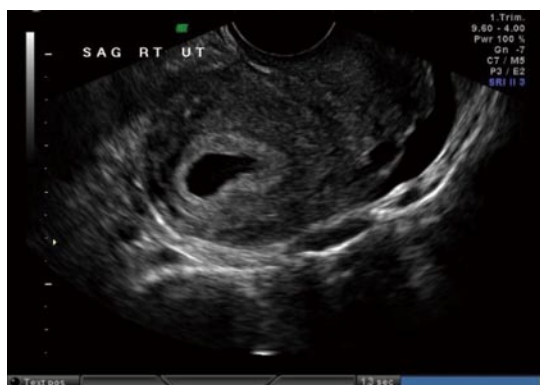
Transvaginal ultrasound image of a fluid collection within the endometrial cavity, a pseudosac, consistent with an extrauterine pregnancy.
